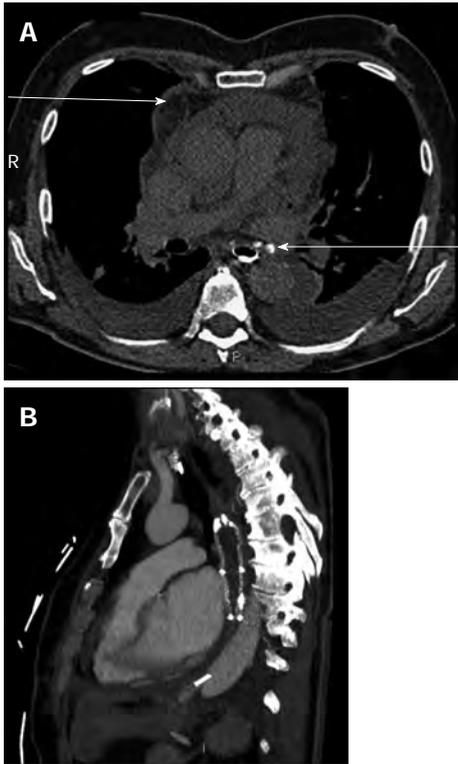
Computed tomography-scan. A: Computed tomography (CT)-scan with esophageal opacification. Pericardial effusion (upper arrow) and esophagopericardial fistula (lower arrow) were both present; B: CT-scan performed after esophageal stent placement and surgical drainage. Pericardial effusion was no longer present following esophageal stent insertion.
